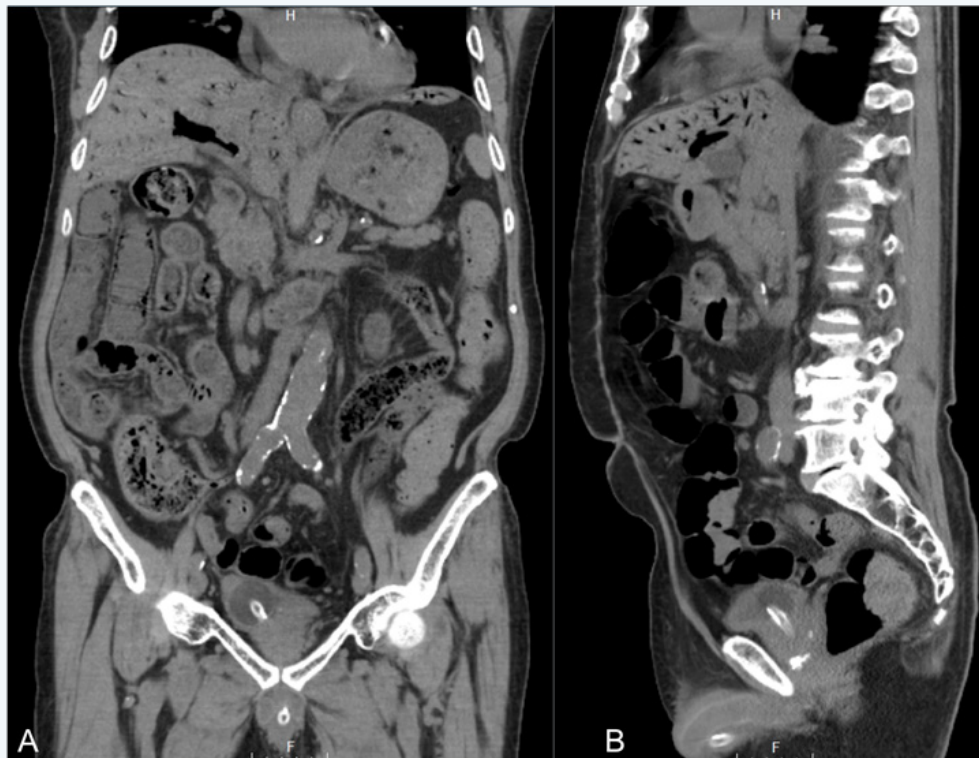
Non-contrast CT of the abdomen and pelvis on admission.
